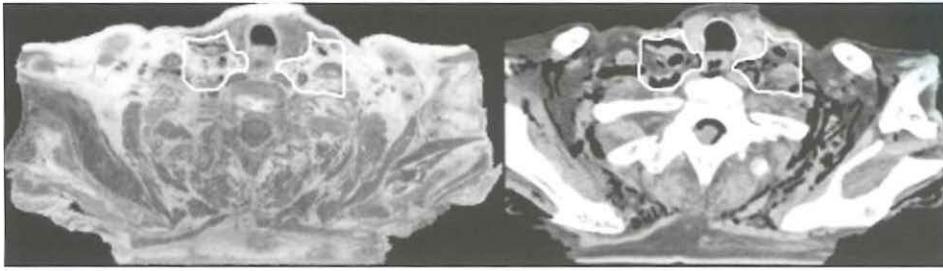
Region 4 (low-jugular lymph nodes): The borders of this region are outlined on a transversal anatomy slice (left panel) and the matched CT slice (right panel), in between the cranial (one slice below the thyroid cartilage) and caudal (2 cm cranial to sternoclavicular joint) borders. The borders are discussed in the text and in Table 1.
